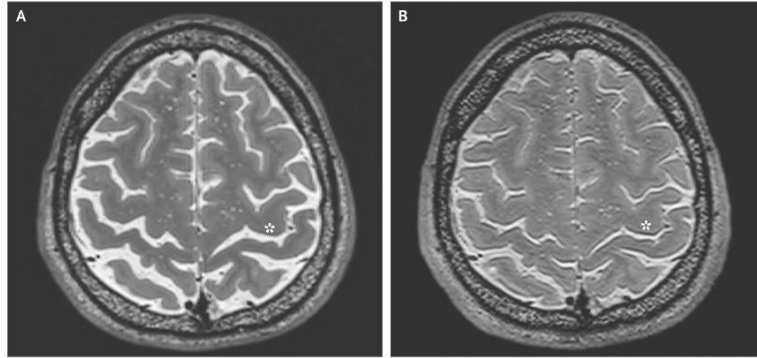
Pre-flight MRI (A) compared to post-flight MRI (B), note the narrowing of the grooves (or sulci), specifically the central sulcus [14].
